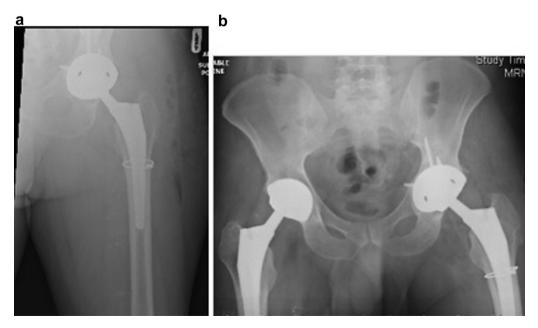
AP left hip (a) and pelvis radiographs (b) after left revision total hip arthroplasty to ceramic head with polyethylene liner.
